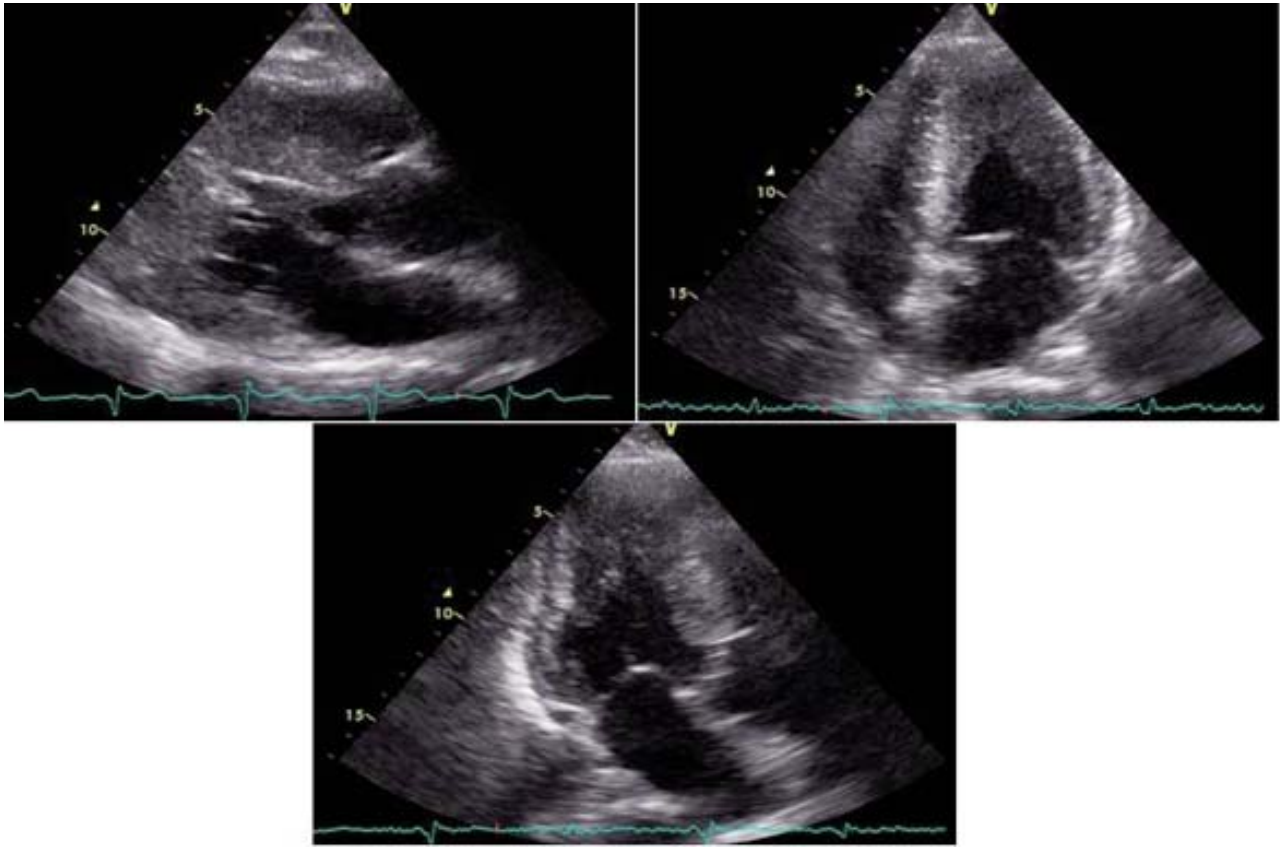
Transthoracic echocardiography demonstrated left ventricular hypertrophy in the apical area with an "Ace-of-spades" configuration in the diastolic phase which is one of the signs of ApHCM seen in view (PLAX; apical 4-chambers; and apical 3 chambers).
